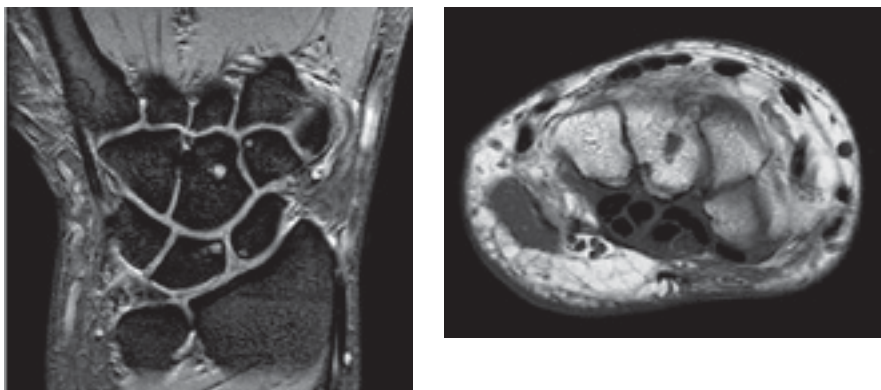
The GE ONI Extreme 1.5T MR offers Spruce MRI Associates a variety of sequences such as FSE, GRE, and FSEfw (SmartFat-fat water separation technique). These wrist images are a T2* GRE coronal (left) and a T1 axial (right).
